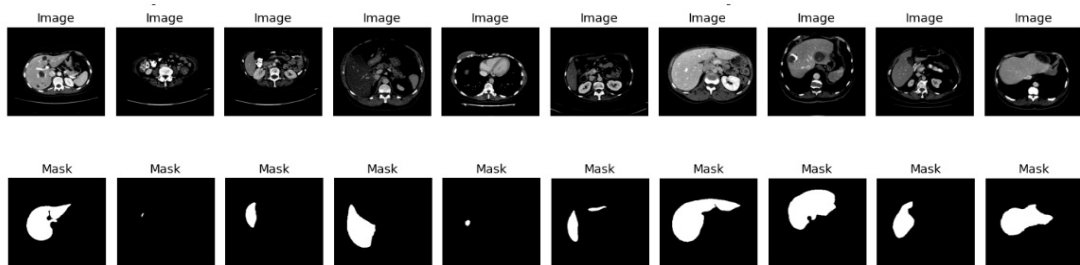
Samples of 3D-IRCADb-01 Dataset, the first set of images represents CT image, followed by the corresponding liver masks.
